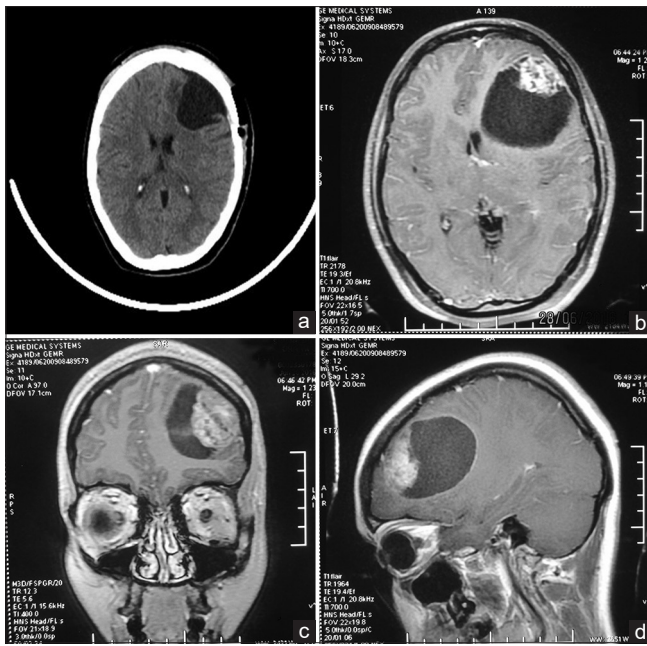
Cranial computed tomography and magnetic resonance imaging revealed a large cortical-based lesion of approximate size 5.7 cm × 5.3 cm × 4.4 cm in the left frontal lobe, causing a significant midline shift to the left. The lesion is predominantly cystic, with suppression on fluid-attenuated inversion recovery with a peripherally based heterogeneous mural nodule showing contrast enhancement. (a) Computed tomography scan showing tumor, (b) magnetic resonance imaging axial, (c) magnetic resonance imaging coronal, (d) magnetic resonance imaging sagittal
